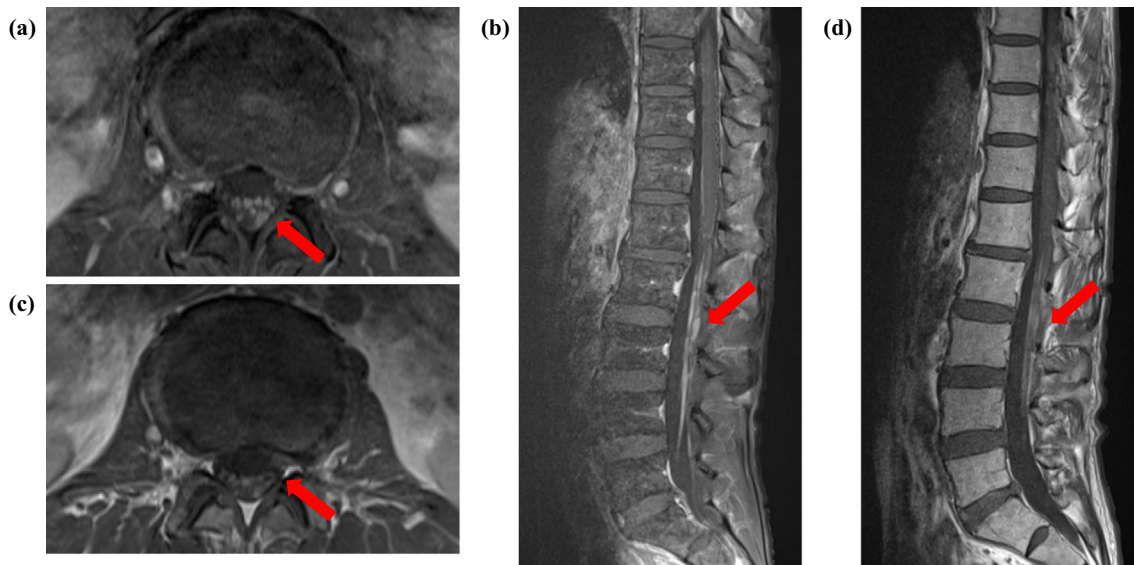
Contrast-enhanced MRI of the patient's cauda equina roots (T1 post-contrast) obtained before and after the initiation of tirabrutinib. (a) Axial-enhanced image of L2/L3 Level on day -10. (b) Sagittal-enhanced image on day -10. Arrows show lesions. (c) Axial image at the L2/L3 Level showing resolution of the enhancing lesion (arrow) on day 79. (d) Sagittal image showing resolution of the enhancing lesion (arrow) on day 79.
